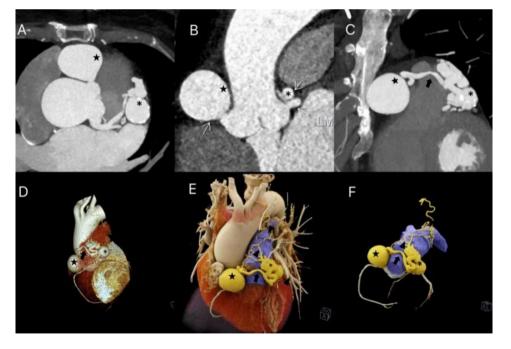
CTA images in a 61-year-old female patient with coronary-pulmonary artery fistulas (CPAFs) with multiple coronary artery aneurysms (CAAs) and Vieussens' arterial ring (VAR). Transverse section (A), coronal section (B) and sagittal section (C) of CTA showing CPAFs with multiple CAAs and formation of VAR. (D-F) Reconstruction images of CTA showing CPAFs, CAAs and VAR.
